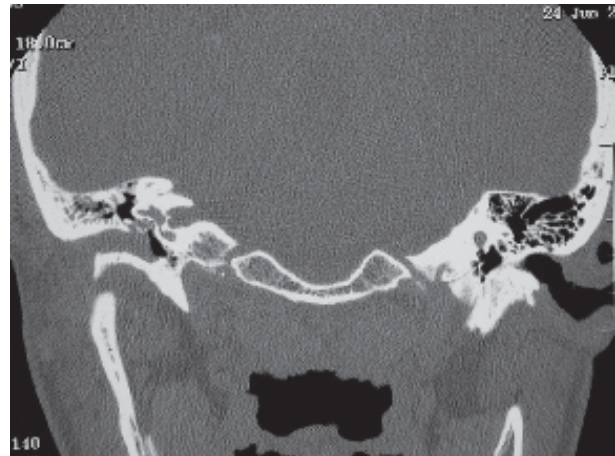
CT of the temporal bone shows the soft-tissue mass involving the right external auditory canal and middle ear.
